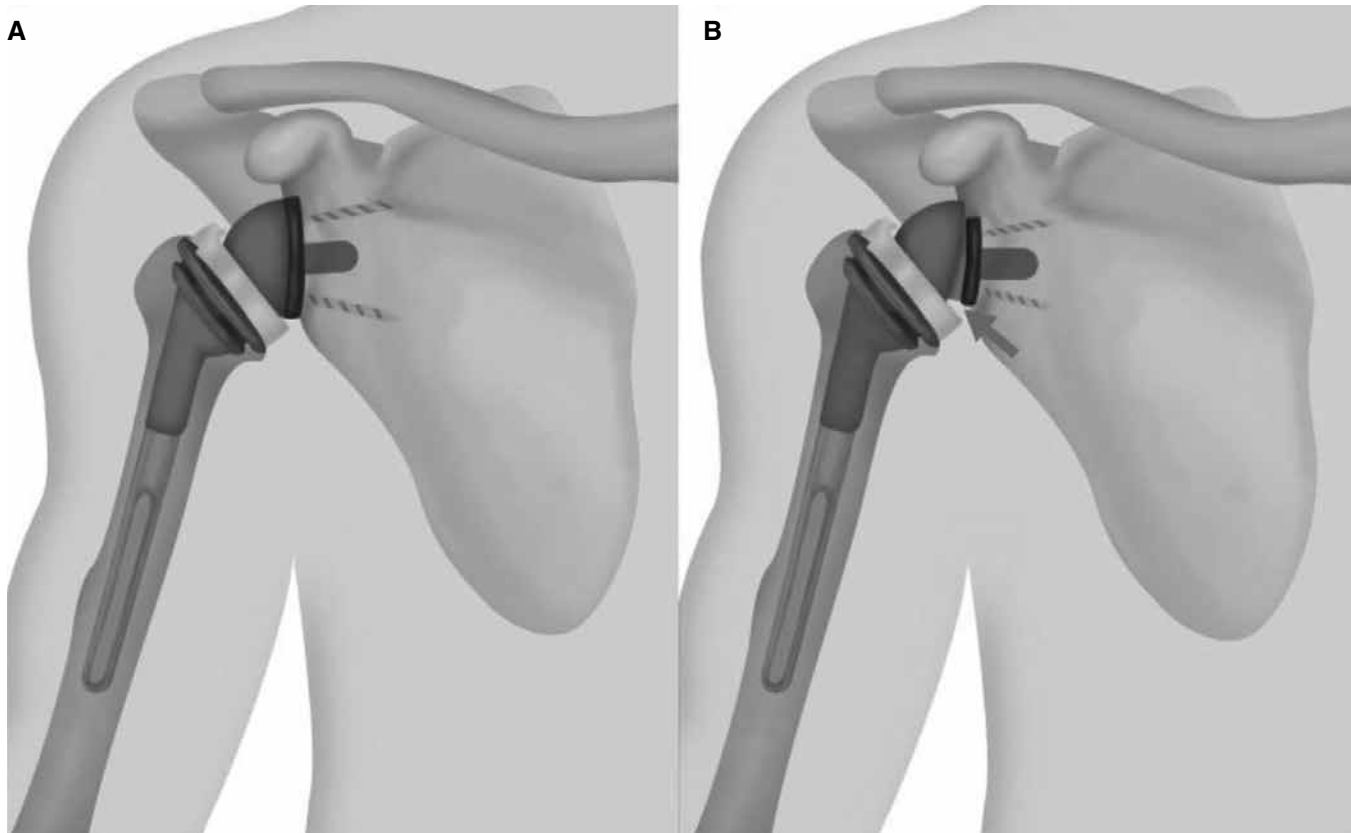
(A) A graphical rendering of the reverse shoulder arthroplasty prosthesis and (B) the incompletely seated glenosphere component with cephalad tilt as seen on post-operative x-rays.
